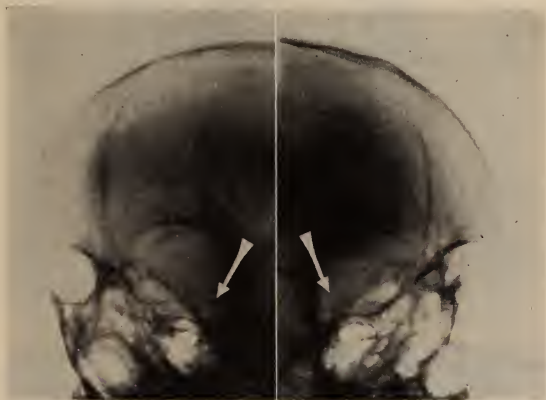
X-ray visualization of the optic foramina, showing enlargement on the right side
